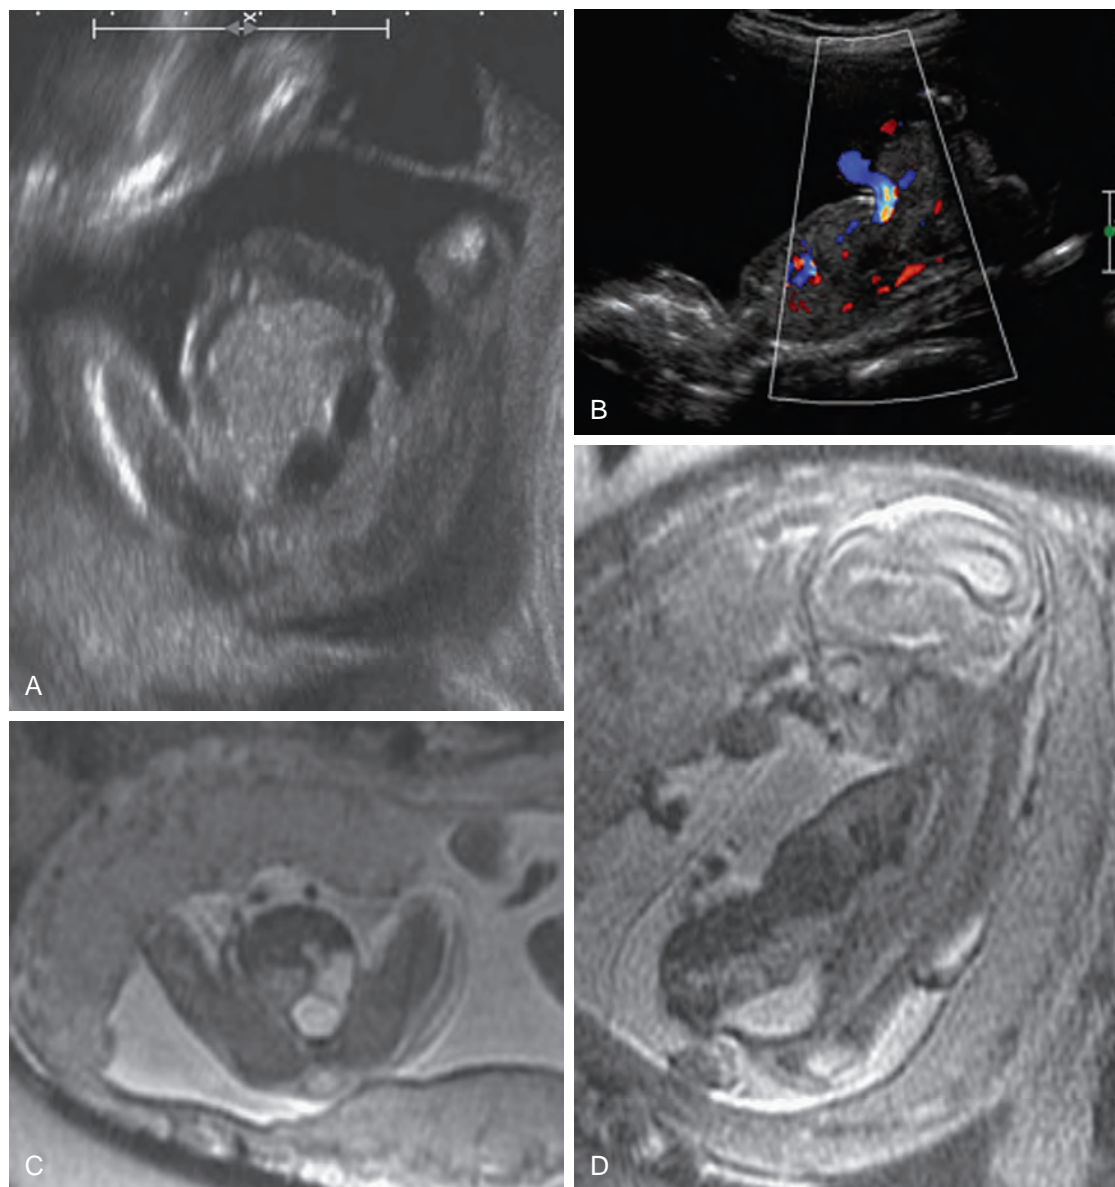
Appearance of cloacal exstrophy on imaging of a 19-week gestational age male fetus. A, Transverse ultrasound image through lower abdomen showing abdominal wall mass and consistent nonvisualization of the urinary bladder. B, Sagittal ultrasound view showing umbilical blood flow and lower abdominal wall mass immediately caudal to the umbilicus. C, Transverse magnetic resonance image showing omphalocele with liver and dilated distal left ureter. D, Sagittal magnetic resonance image with omphalocele, ureter, and terminal myelocystocele evident.
